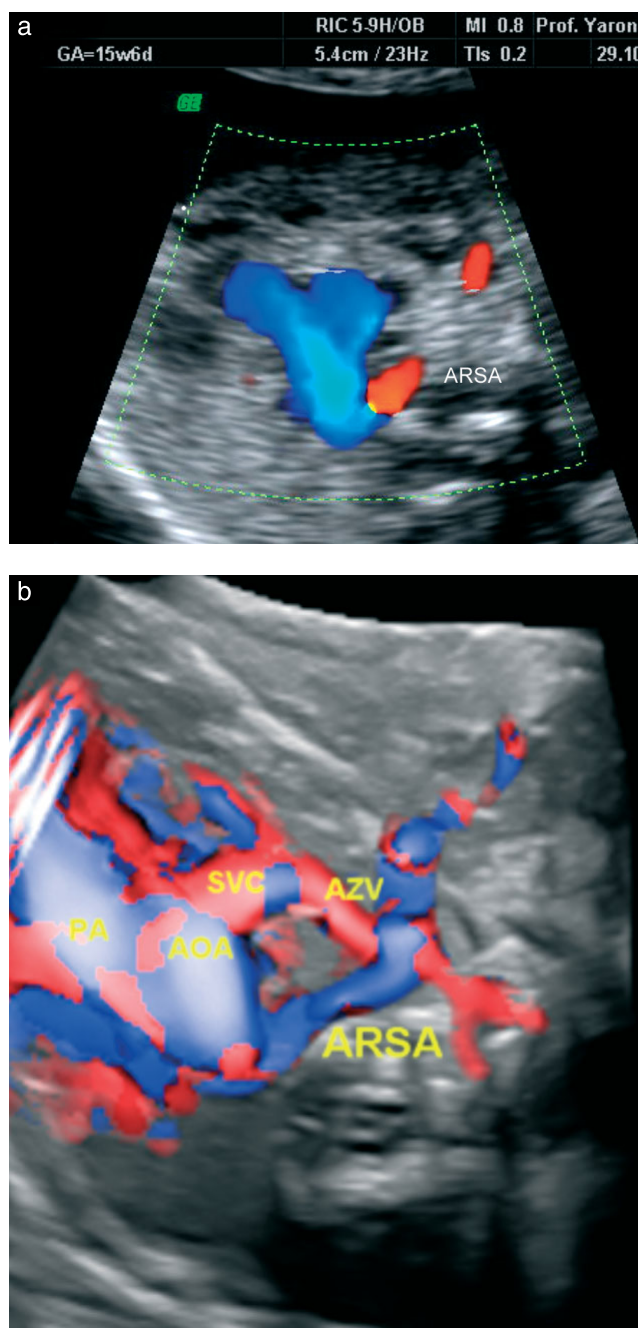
Two-dimensional (a) and three-dimensional (b) visualization of aberrant right subclavian artery (ARSA) using color Doppler imaging. AOA, aortic arch; PA, pulmonary artery; SVC, superior vena cava; AZV, azygos vein.
